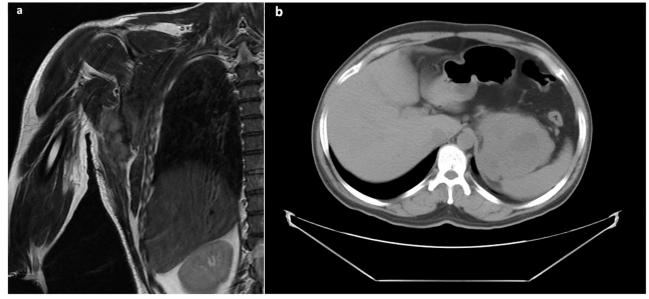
a) MRI of the right shoulder showed a 6.5×6 cm lesion involving muscular plane, infiltrating right latissimus dorsi and subscapularis. b) Computed tomography of the abdomen which showing an exophytic mass with central necrosis of size 8×7.2 cm in the gastro esophageal junction with loss of fat plane with left adrenal and spleen
